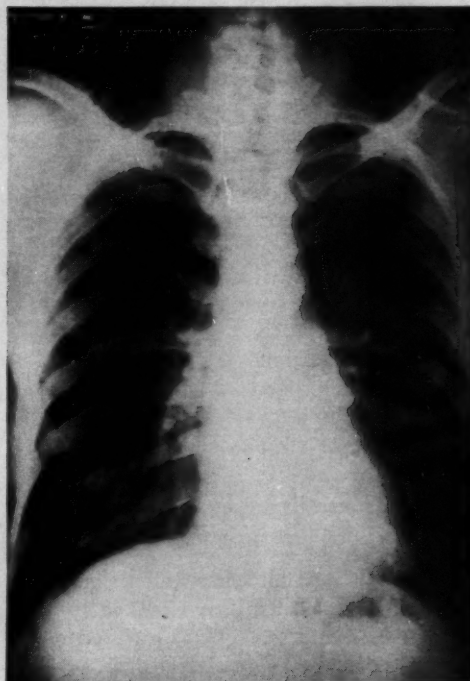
Patient No. 4—routine chest x-ray showing no abnormalities of significance.
